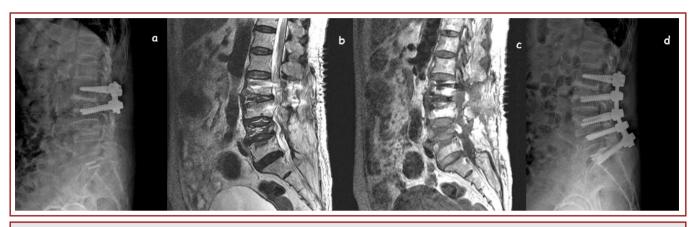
a) At 7 days after surgery, decreased vertebral body height in lateral plain X-ray was found at L4. b-c) At 7 days after surgery, MRI scans showed a bursting fracture at L4 with epidural hematoma and a compression fracture at L5. d) She underwent extended laminectomy at L4, removal of epidural hematoma, and re-instrumentation with pedicular screws from L2 to S1.
